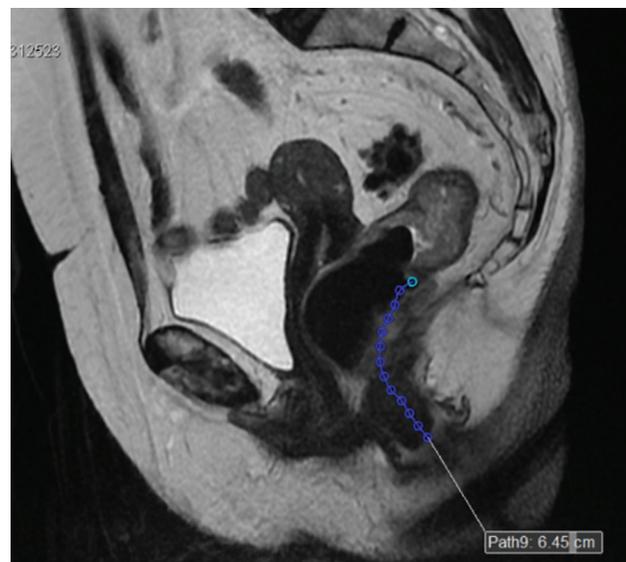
Sagittal section on magnetic resonance imaging showing vegetative lesion in the middle part of the rectum (MRI).
